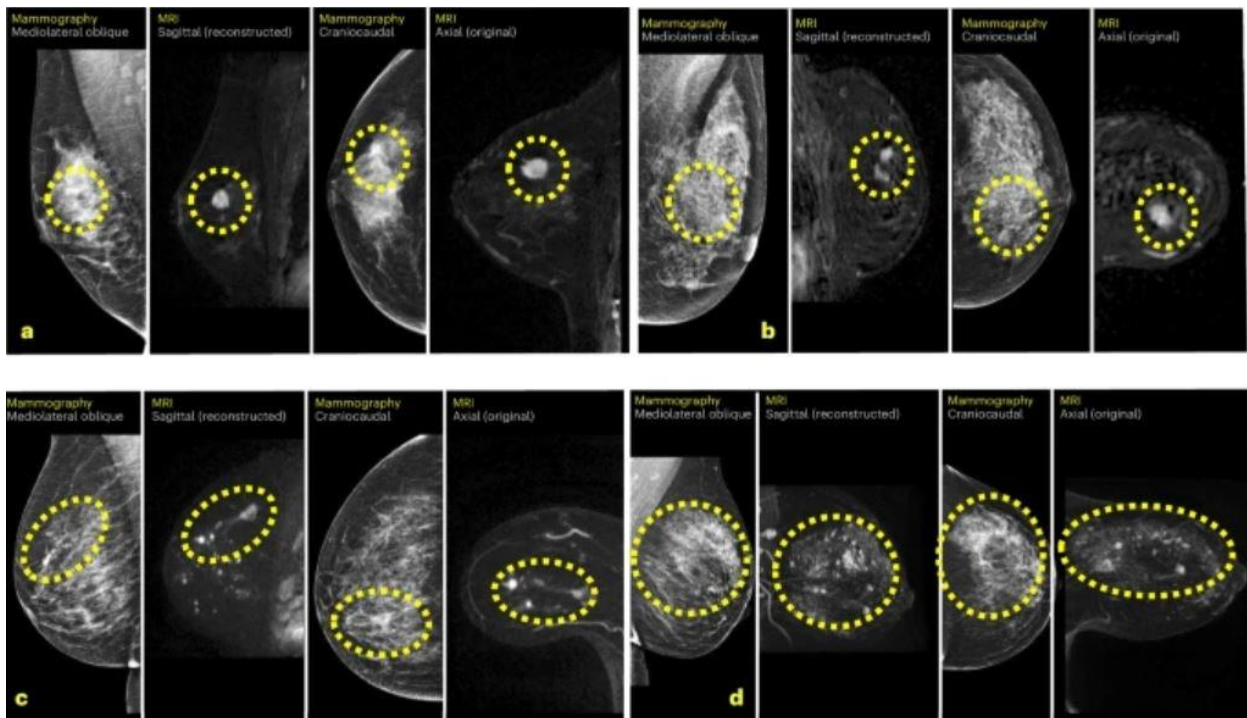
Comparative visualization of breast tumors on mammography and magnetic resonance imaging (MRI). Lesions marked with yellow dashed lines are partially detected on mammography, whereas MRI provides more precise visualization of tumor size and extent.
